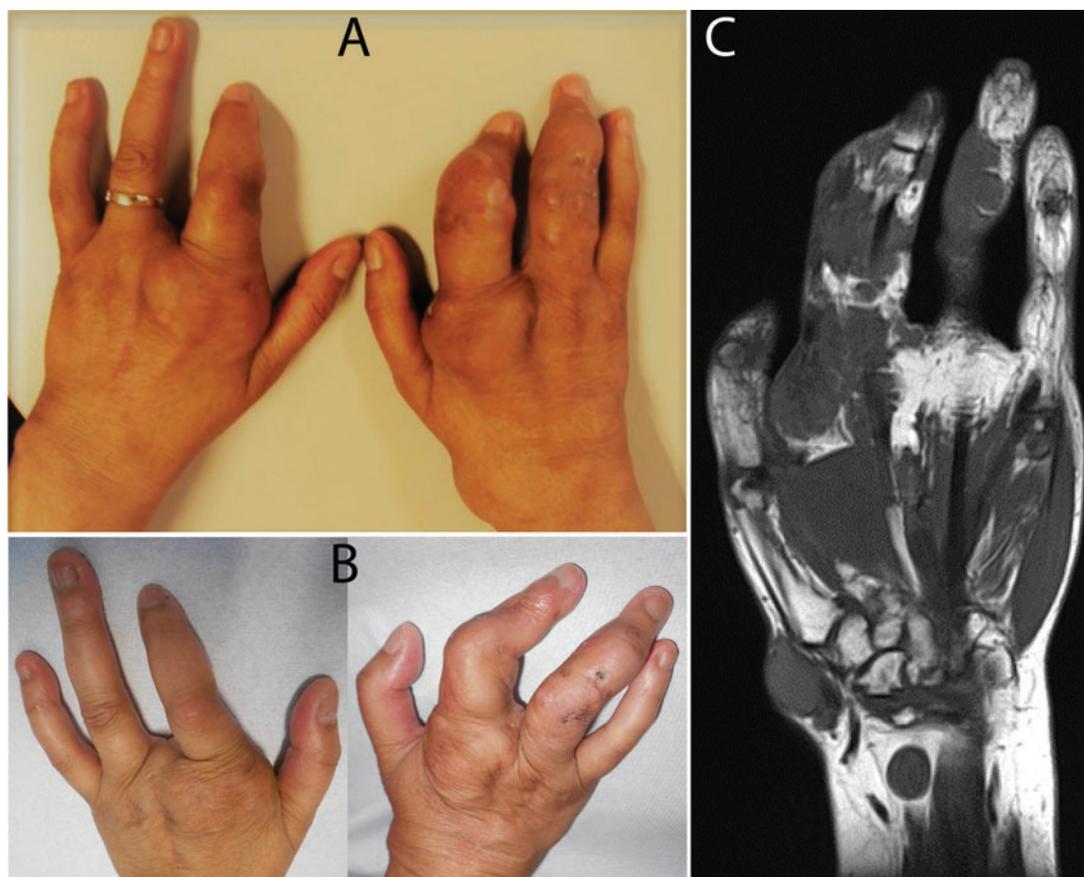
Massive nodular deformations and palpable subcutaneous soft nodules (A). At 2-year follow-up, nodules substantially regressed upon treatment with baricitinib (C). MRI right hand with pronounced and widespread soft tissue deposits (B).
